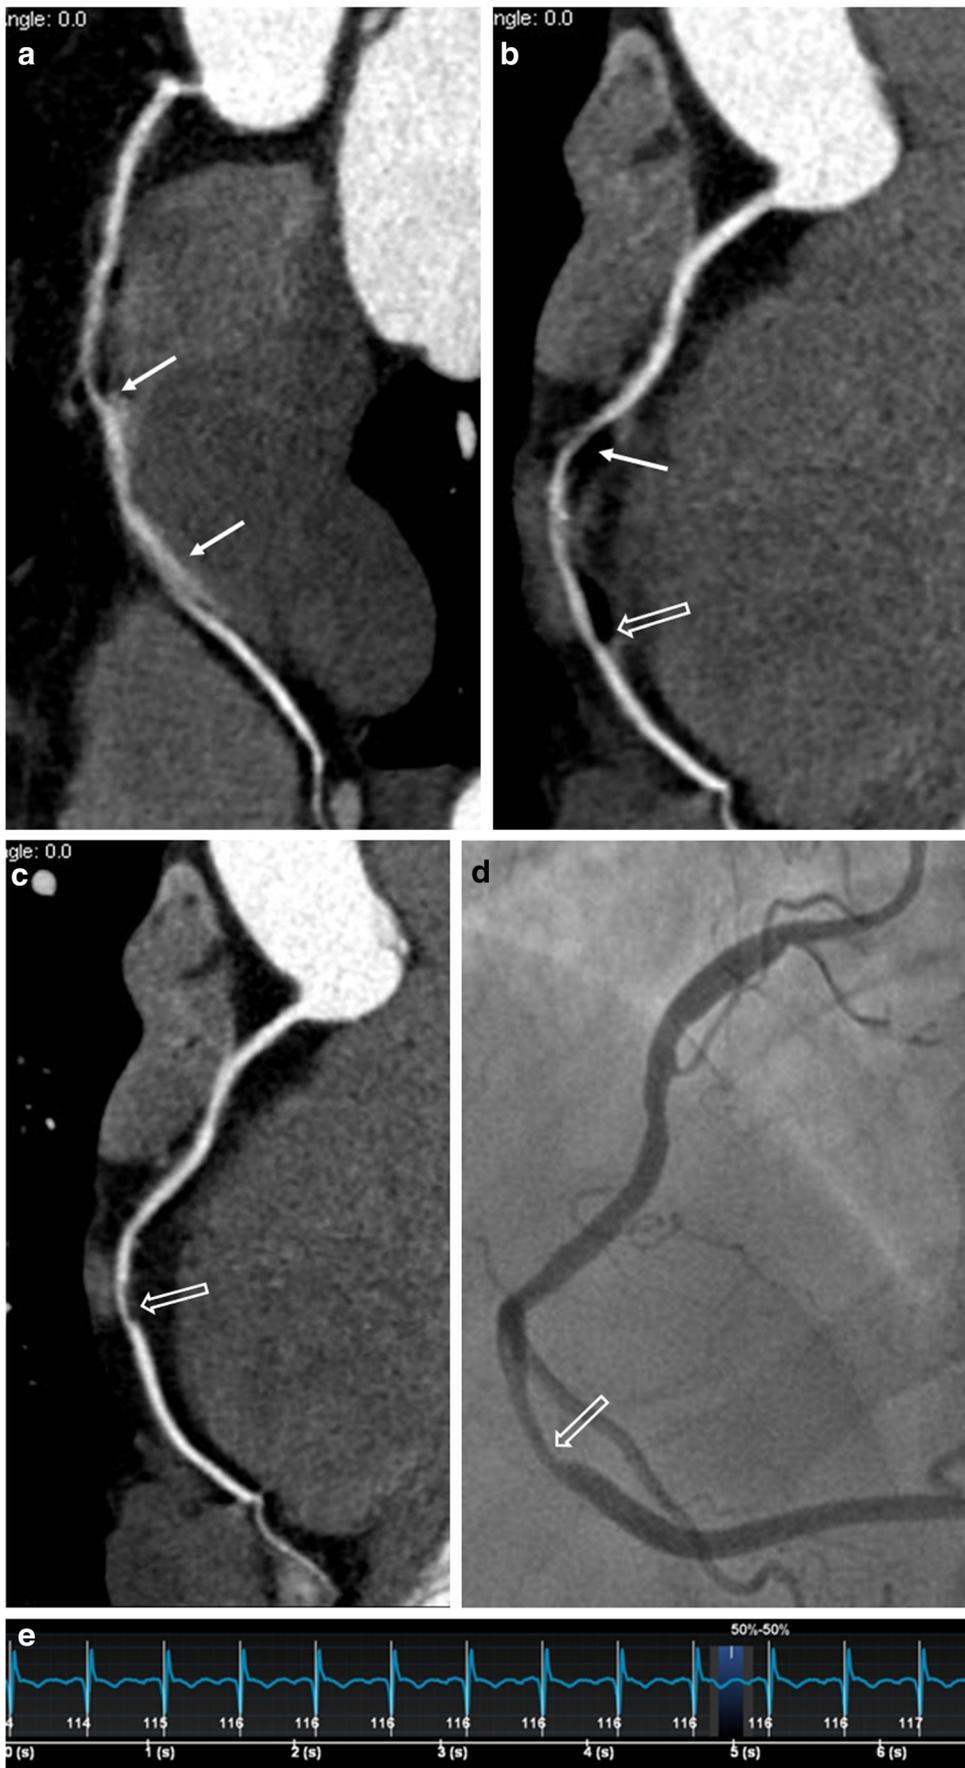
A 63-year-old man with a body mass index of 28.69 kg/m<sup>2</sup> was suspected with coronary artery disease. The effective dose from coronary CT angiography was 0.86 mSv. Curved multi-planar reformats image (a) with standard algorithm shows motion artifacts (arrow) and affect the significant stenosis at mid-segment of left anterior descending (LAD). Image (b) with MC1 shows less motion artifacts (arrow) and suspected
